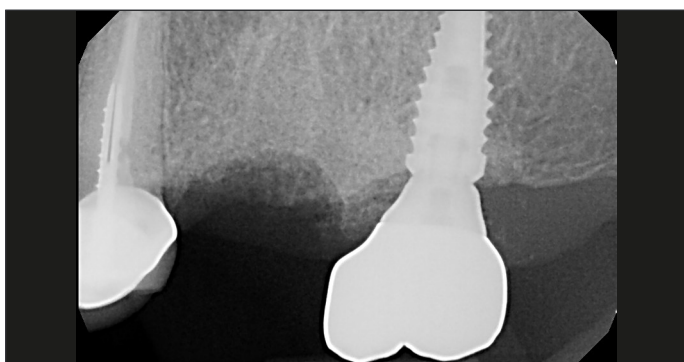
X-ray image after 3 months.
